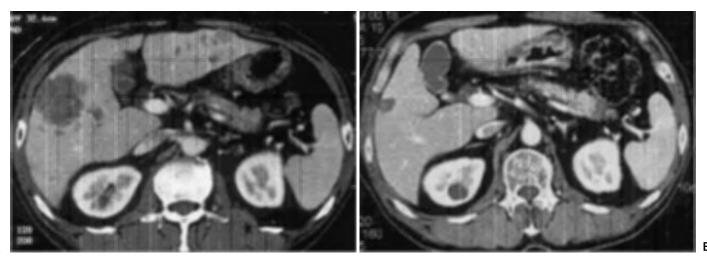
Computed tomography of multiple liver metastases in case 1, A before and B after combination chemotherapy
